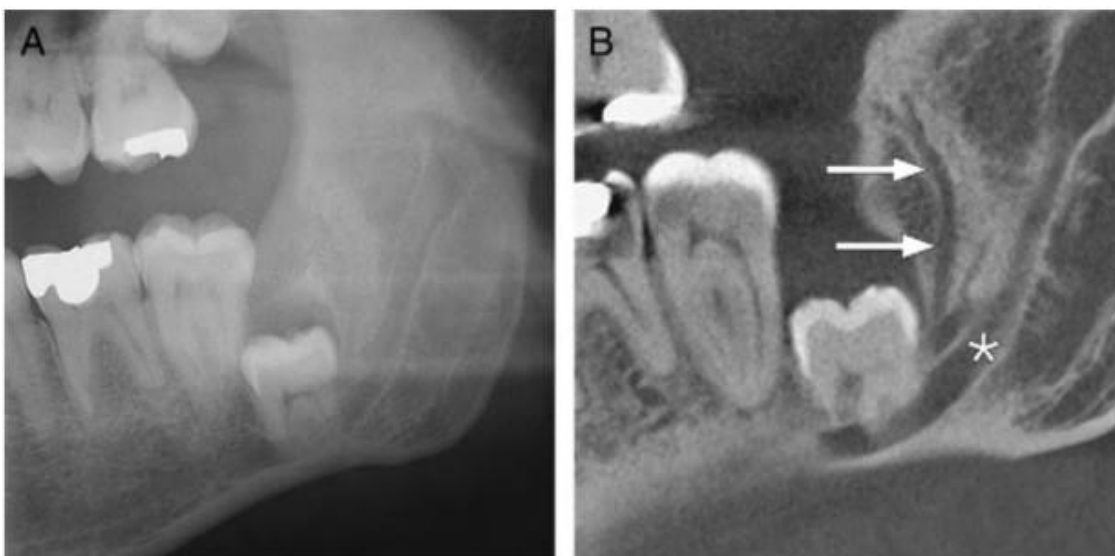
Comparison between the CBCT scan and a PAN of the same patient where the RMC is not clearly discernable on the PAN. A) PAN without a clear RMC (not clearly visible as a canal between the retromolar area and the inferior alveolar canal); B) Sagittal view of the RMC (arrows) descending into the inferior alveolar canal (asterisk). (21)
